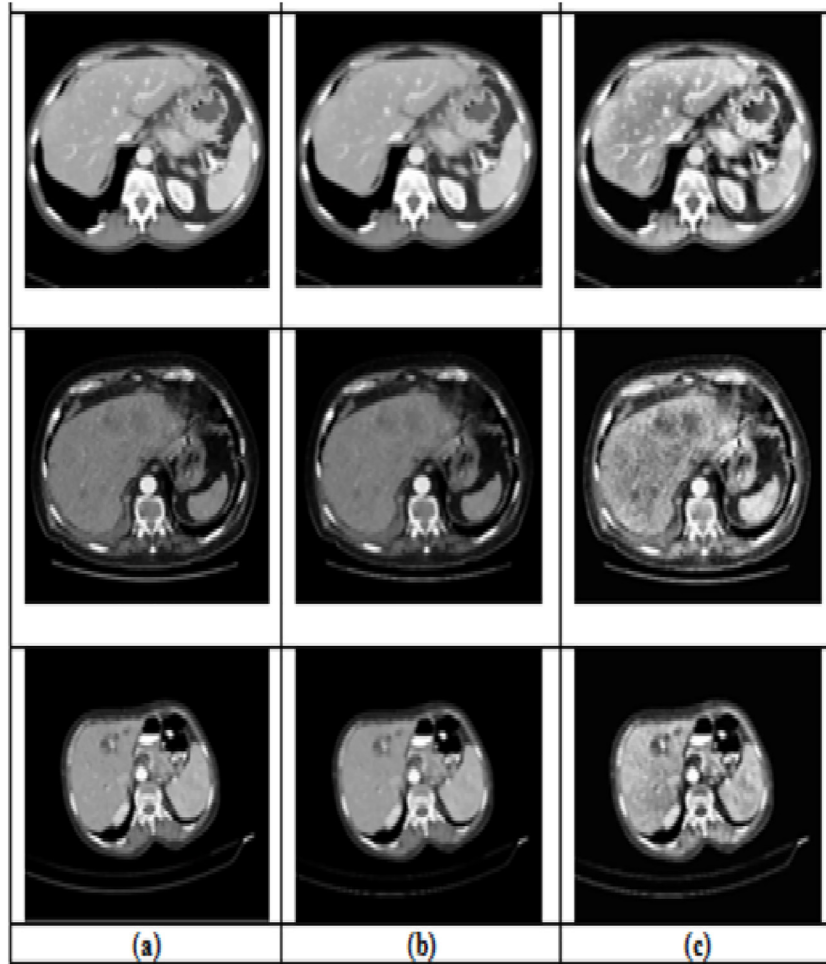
Results of different cases abdominal CT images after enhancement. (a) Original image, (b) image after applying median filter, and (c) image after apply histogram equalization.
